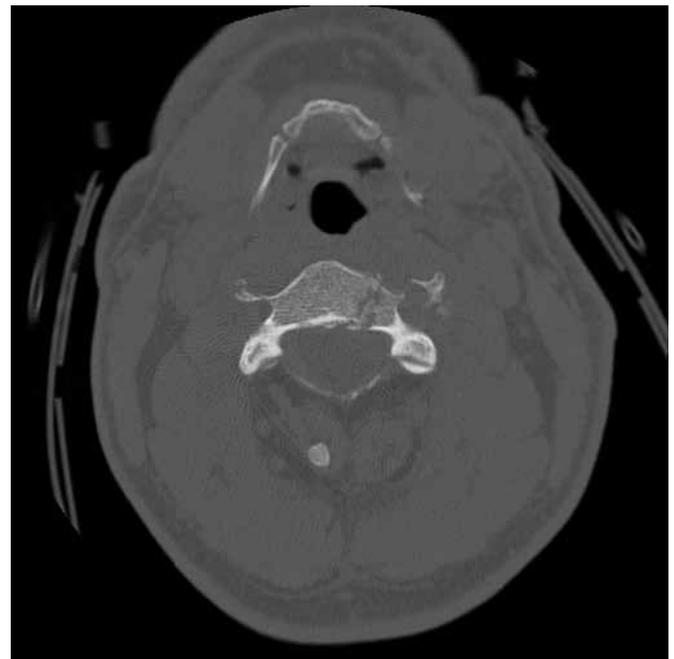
Axial CT image demonstrating C3 vertebral body fracture.
